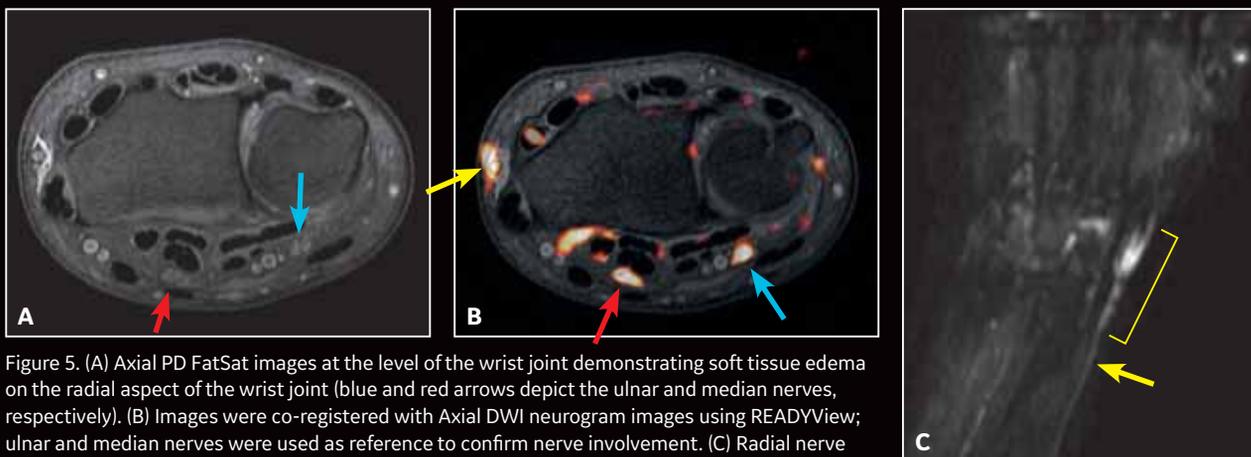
(A) Axial PD FatSat images at the level of the wrist joint demonstrating soft tissue edema on the radial aspect of the wrist joint (blue and red arrows depict the ulnar and median nerves, respectively). (B) Images were co-registered with Axial DWI neurogram images using READYView; ulnar and median nerves were used as reference to confirm nerve involvement. (C) Radial nerve shows a short segment of restricted diffusion proximal and distal to the wrist joint (yellow bracket) suggesting traumatic radial neuropathy.
